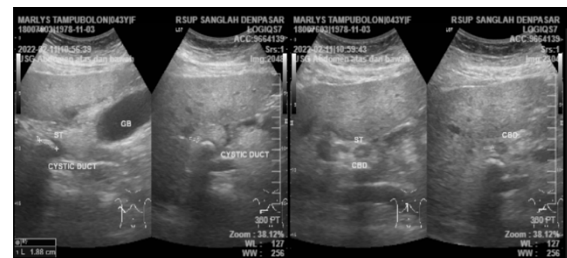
Gallbladder ultrasonographic findings.
